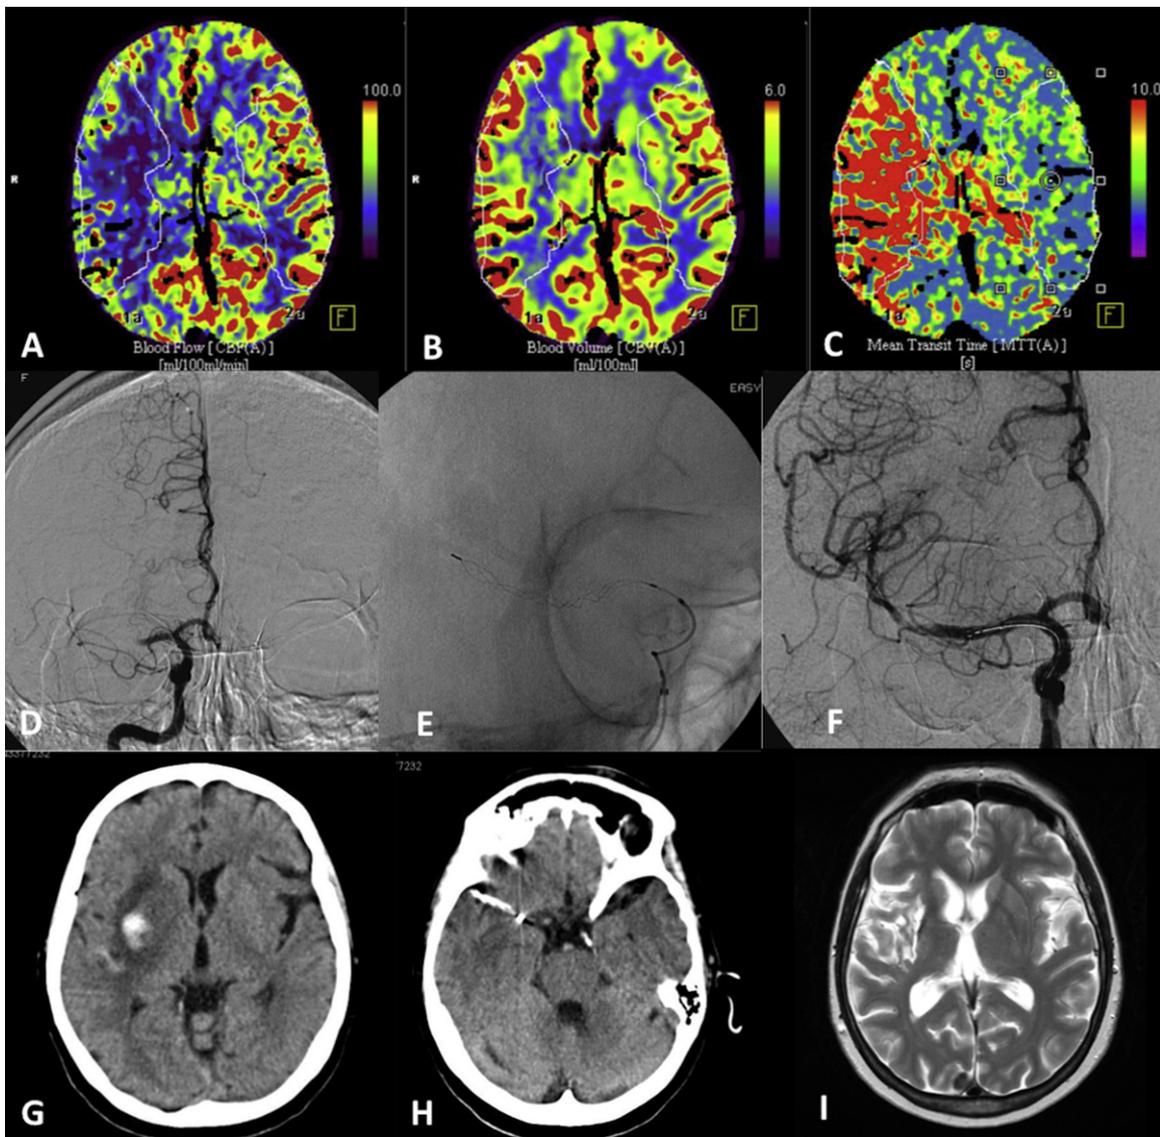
(A, B, C). Patient presenting with occlusion of the right MCA; pre-treatment CT perfusion shows wide perfusional mismatch in the MCA territory. (D). Angiographic study shows occlusion of the proximal M1 segment of the right MCA. (E). Recanalization failure after 4 thrombectomy attempts with Trevo stent-retriever. (F). Restored flow after Solitaire detachment. (G, H). CT scan at 72 h shows haemorrhagic conversion (PH1) of the right basal ganglia. (I). MR (TSE T2-w) at 3 months shows late chronic stage hemorrhagic lesion of the right lenticular nucleus.
